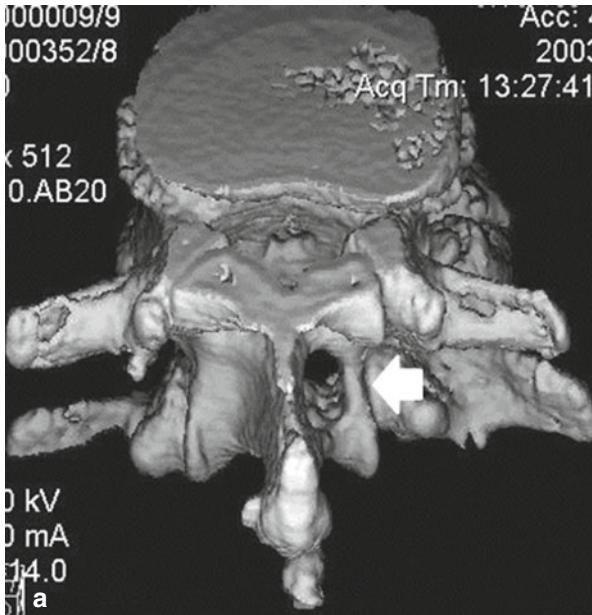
(a) The 3-D CT shows a translamellar hole at L3 on the left side. Note: The facet joint L3/L4 is intact and a sufficient lateral rim (5 mm, *arrow*) of the pars is maintained where the bone is strongest. (b) Intraoperative
